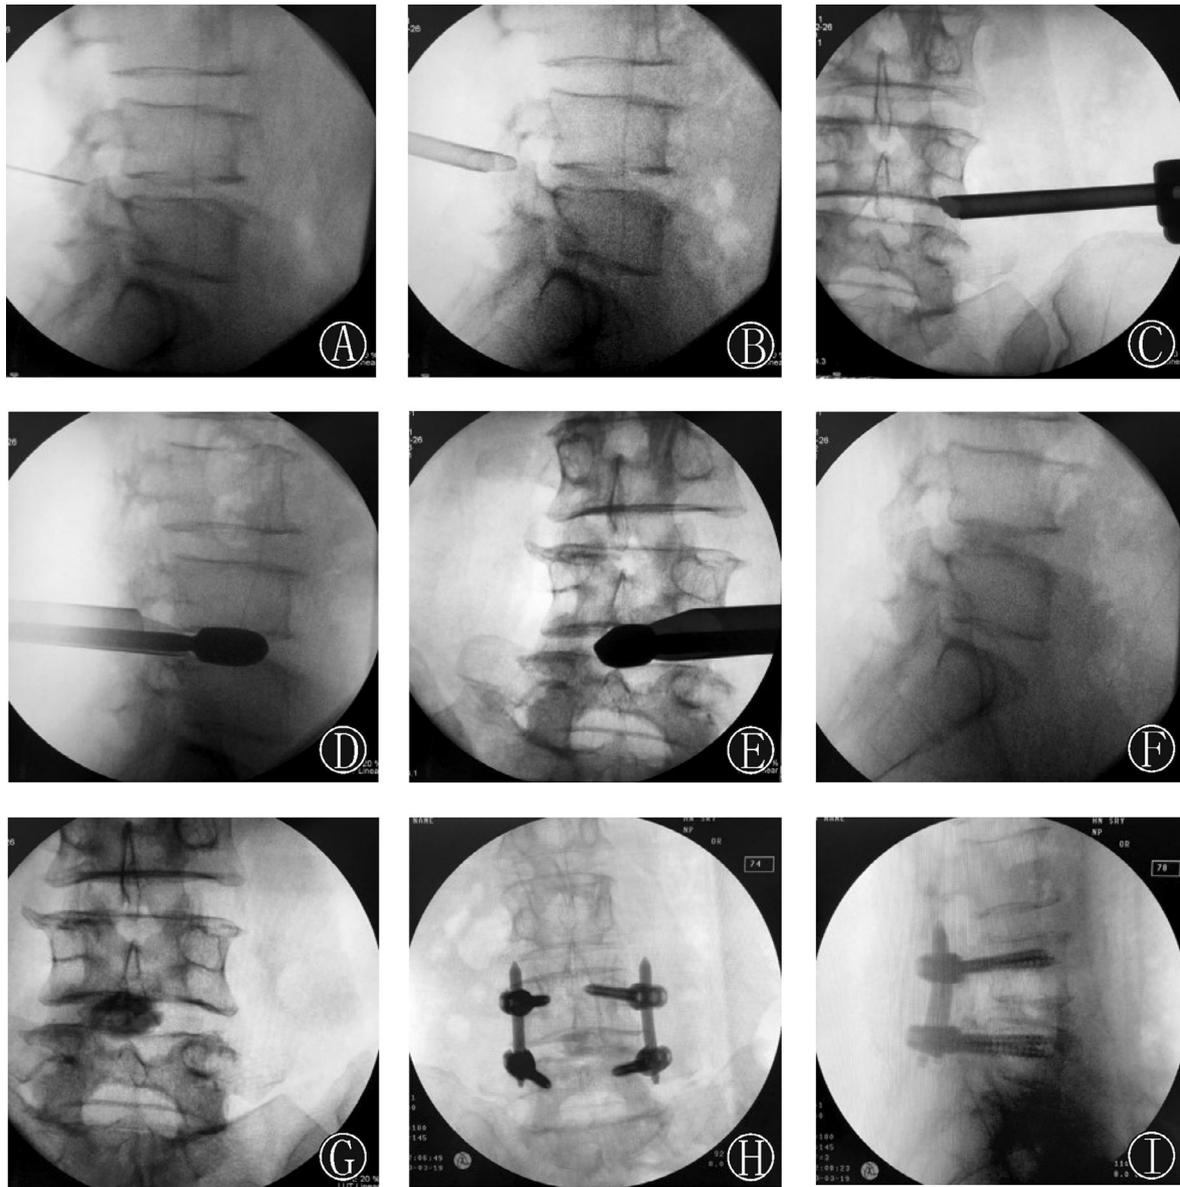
(A). The target site, called the facet joint, was located by inserting an 18-gauge needle under the guidance of the C-arm to identify the L₄₋₅ segment. (B and C). The working channel was rotated slowly along the direction of the guide bar in lateral (B) and anteroposterior (C) X-ray images. (D and E). An image showing a fusion prosthetic device in the disc space. (F and G). An interbody fusion cage was used for fluoroscopic and endoscopic visualization. (H and I). Percutaneous pedicle screw fixation was conducted under fluoroscopic guidance. [Correction added on 15 January 2021, after first online publication: Figure 3 has been amended.]
